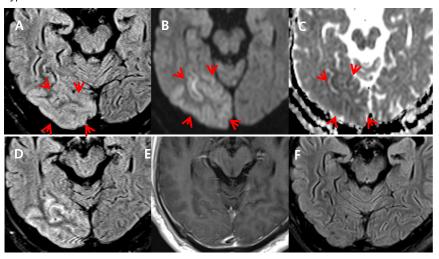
A 58 year old man with seizures associated with NKH. FLAIR image (A) show focal subcortical hypointensity in right occipitotemporal region with hyperintense cortical edema. DWI (B) and ADC maps (C) show restricted diffusion in the corresponding area. CE-FLAIR (D) images show diffuse cortical and leptomengeal enhancement while CE-T1 (E) image shows no significant enhancement. Follow up image (F) 252 days later shows remarkable resolution of the subcortial hypointense lesion and cortical hyperintensity.
